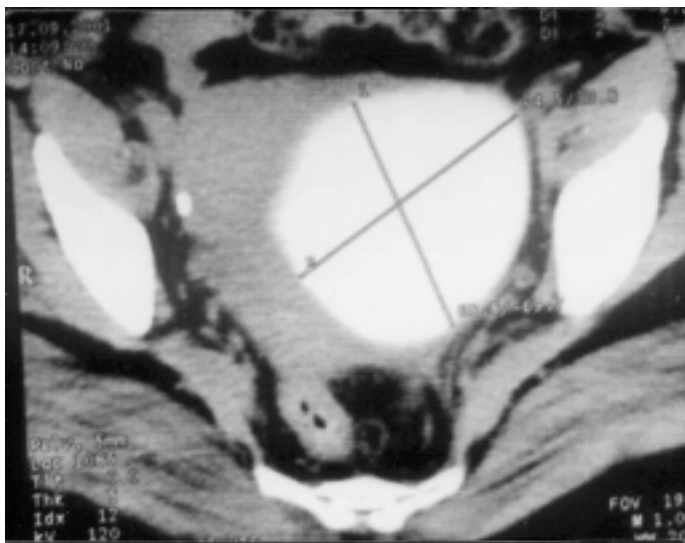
Postembolization pelvic axial noncontrast CT scan showing contrast retention in the fibroid suggesting a successful embolization.
